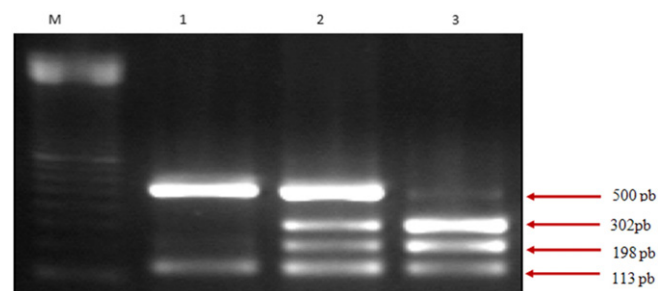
Genotyping of *GCLC* by RFLP PCR. M: 100 bp DNA marker. Lane 1: CC genotype (500 pb and 112 pb). Lane 2: CT genotype (500 pb, 302 pb, 198 pb and 113 pb). Lane 3: TT genotype (302 pb, 198 pb, 113 pb).
